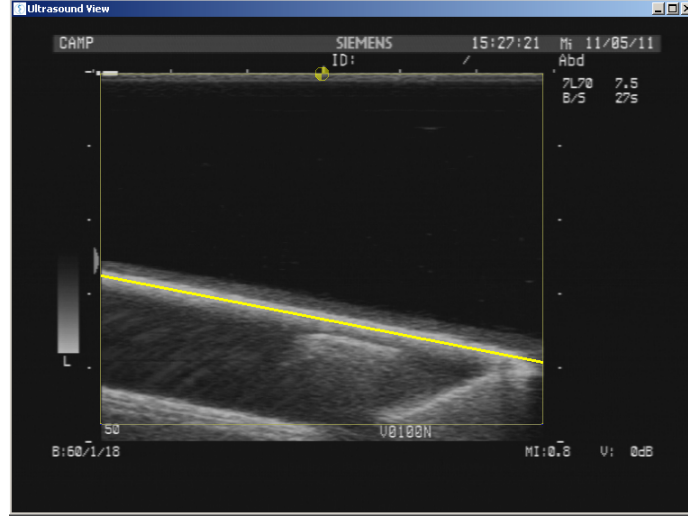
Ultrasound calibration screenshot with automatically segmented nylon membrane.
